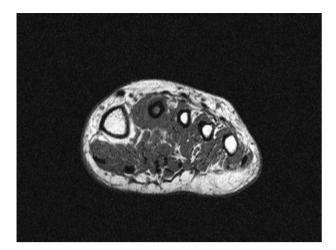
An axial T₁ MRI demonstration of a stress fracture of the second metatarsal bone demonstrating extensive medullary high signal and cortical thickening with soft tissue oedema.
